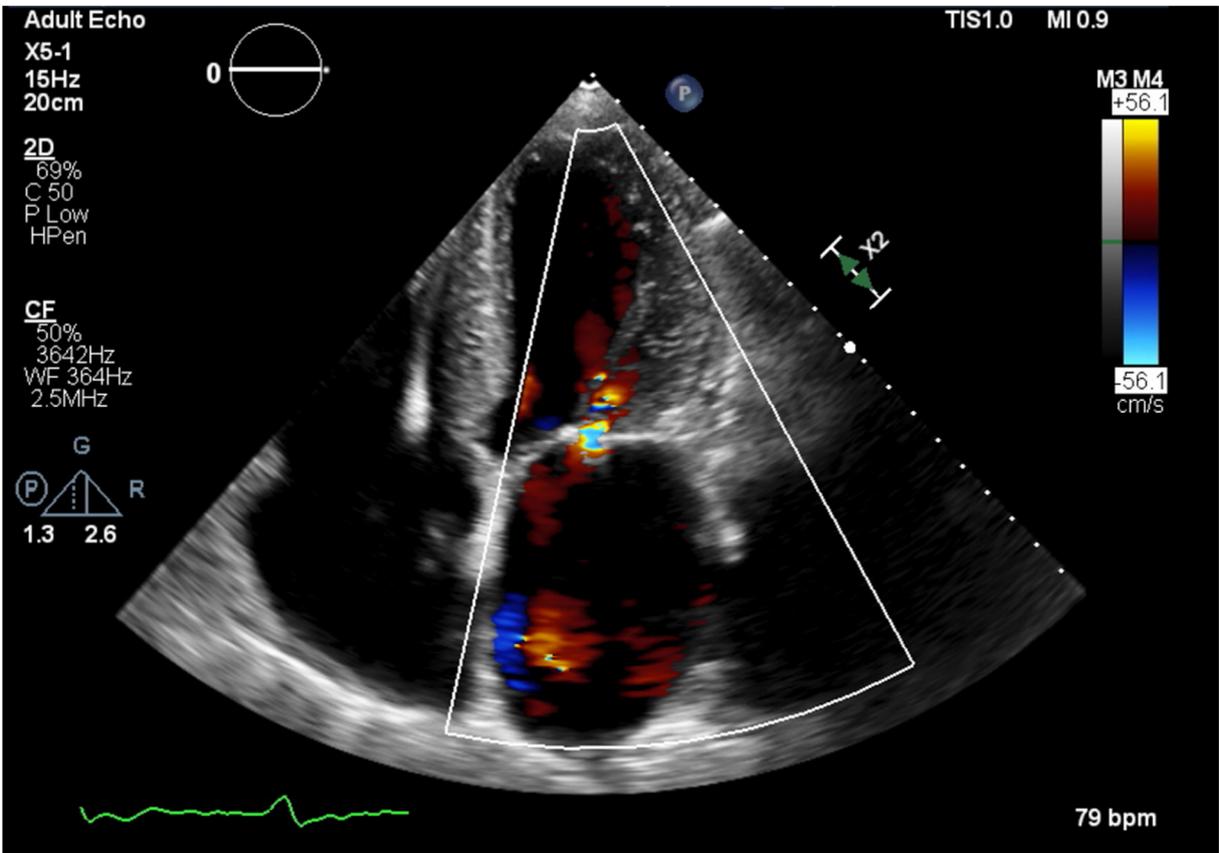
Post procedure TTE in apical 4 chamber view showing mild mitral regurgitation.
